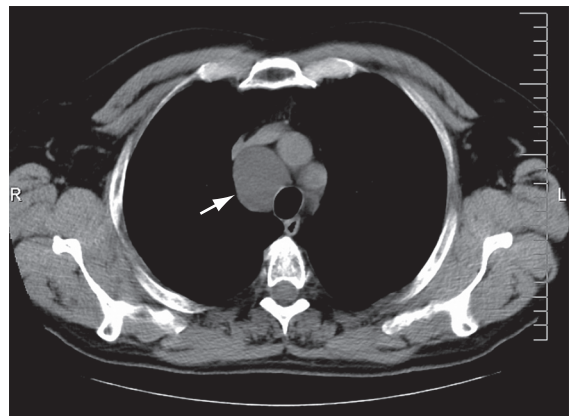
Computed tomography scan of the chest showing an extensive mediastinal lesion (arrow) in contact with the right tracheal wall and causing anterior deviation of the brachiocephalic vein and superior vena cava.
